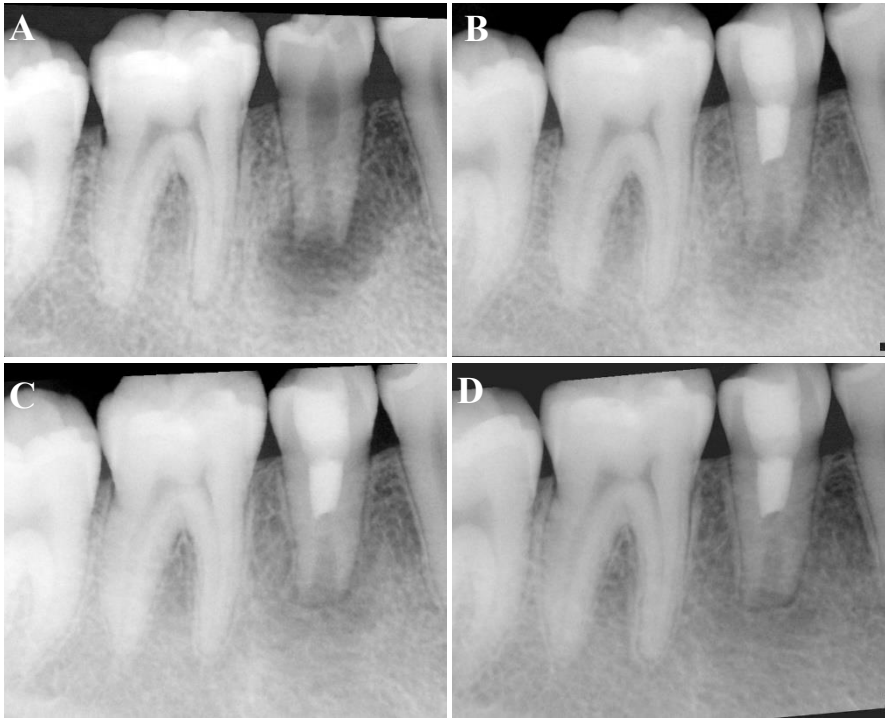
A series of periapical radiographs standardized using TurboReg plugin: (A) preoperative, (B) postoperative, (C) 8 months follow-up, (D) 14 months follow-up.
